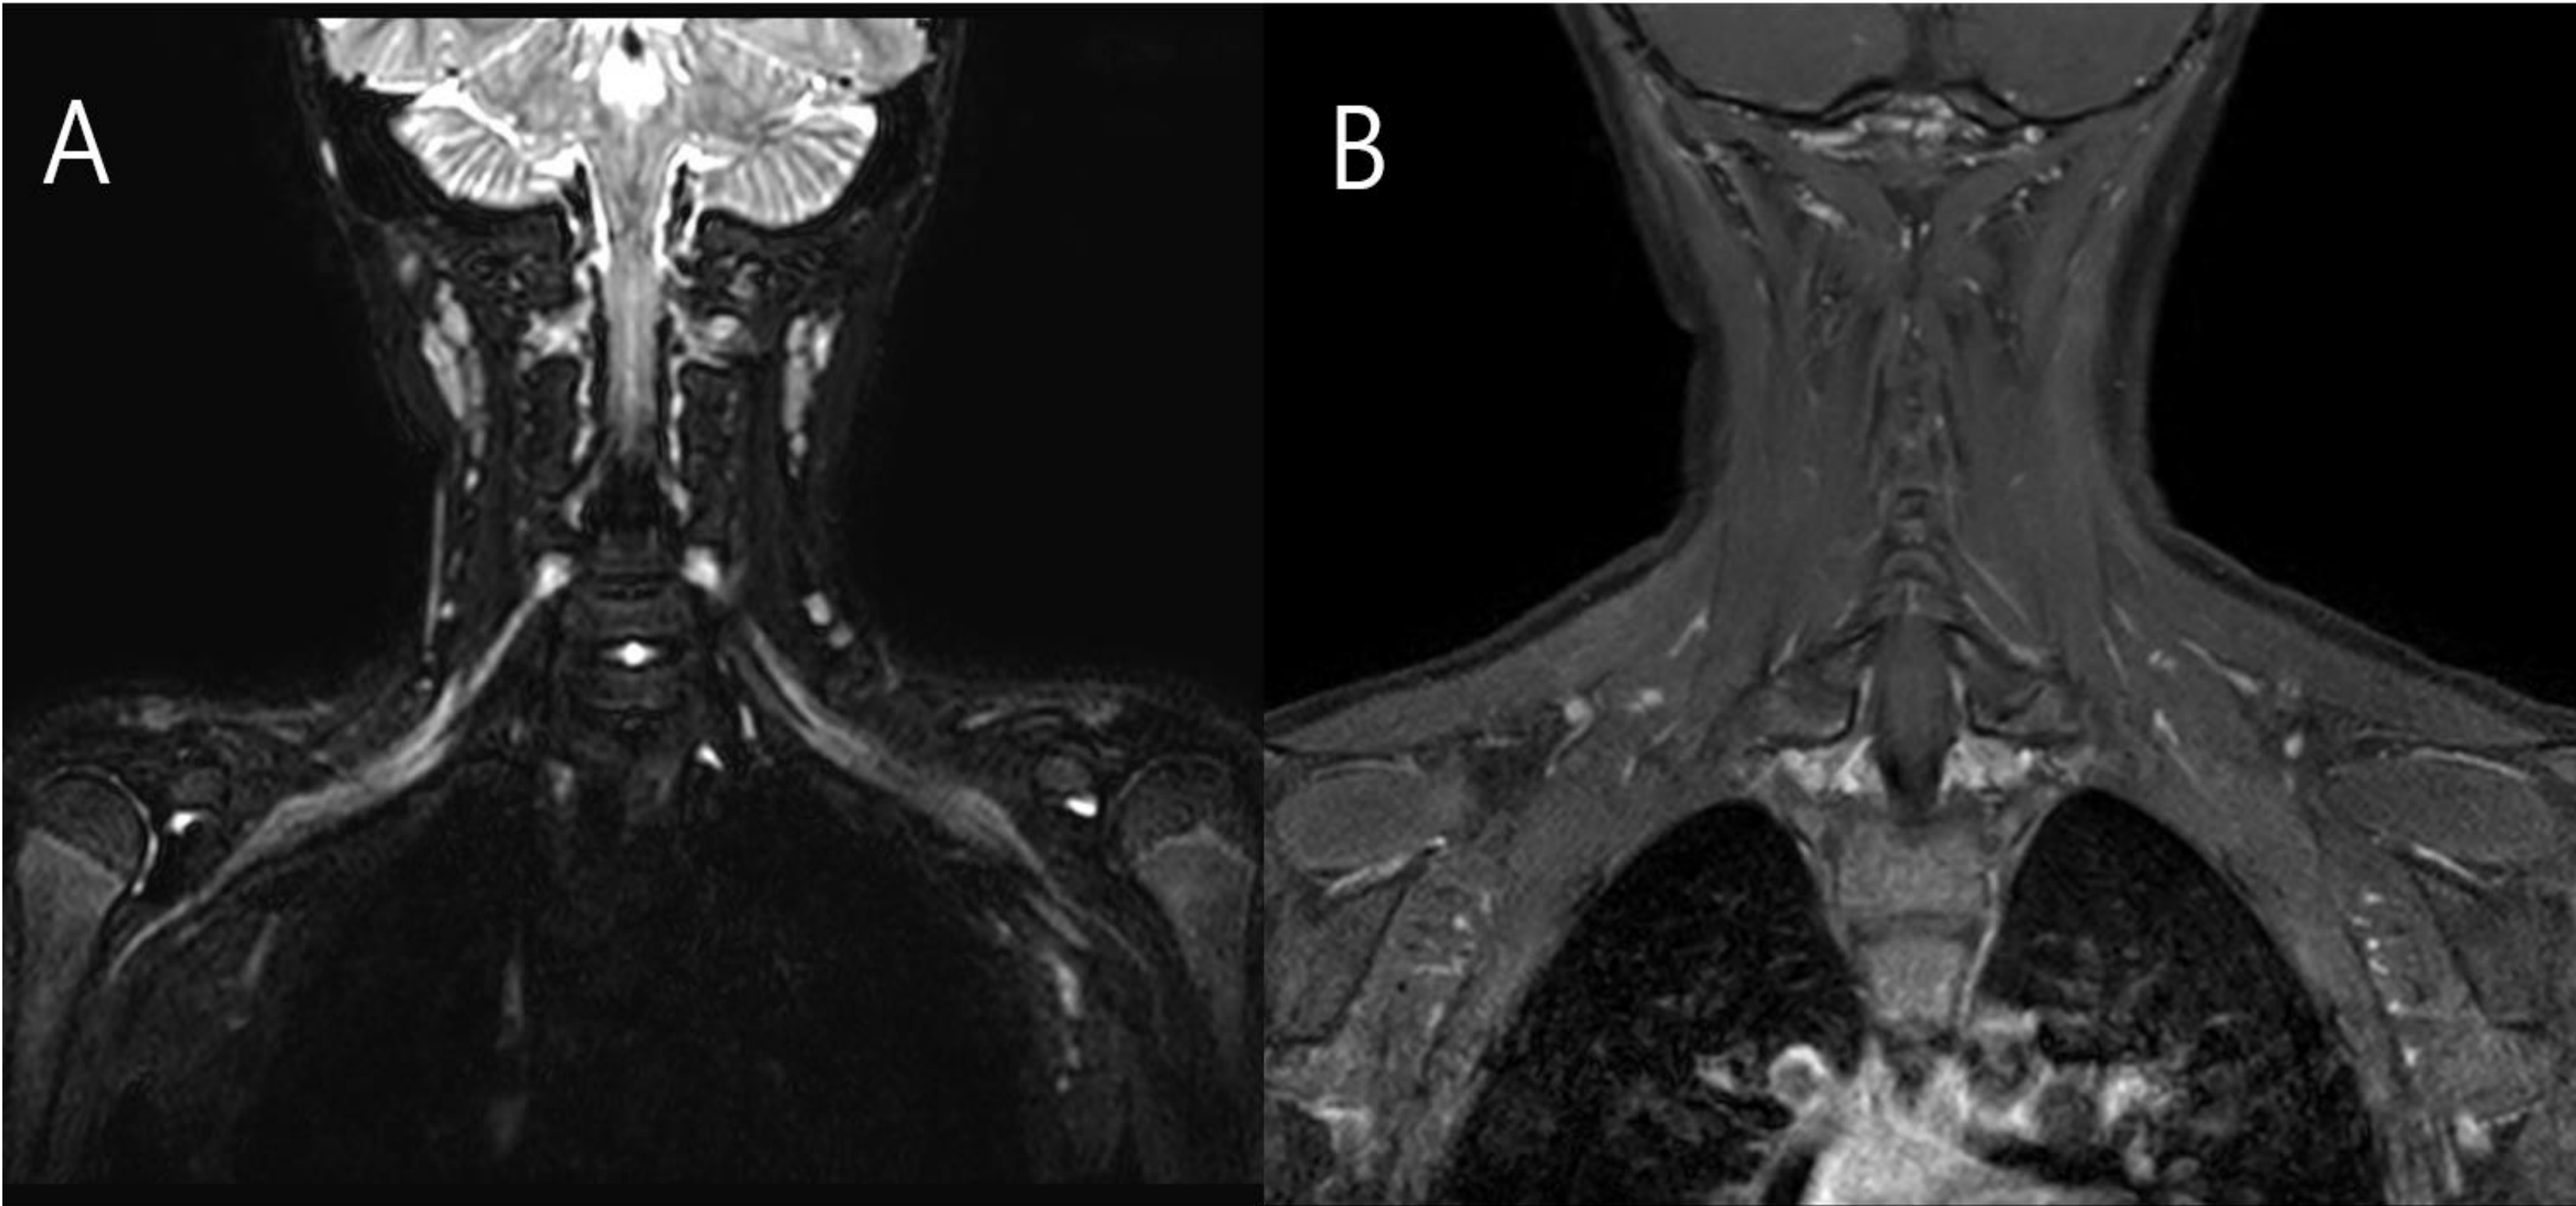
Brachial plexus MRI
